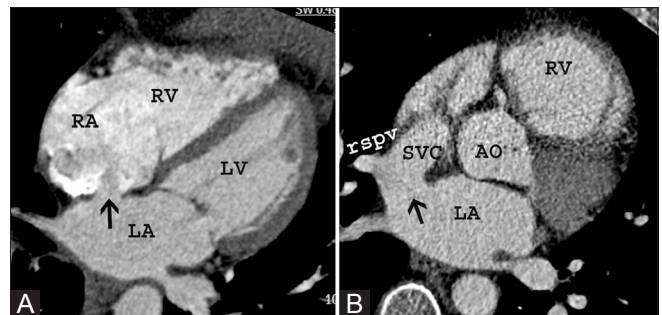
(A, B): Congenital anomalies. Four-chamber CT image (A) shows a defect in the region of the fossa ovalis (arrow), with the contrast jet extending from the left atrium to the right atrium. Axial CT image (B) shows a sinus venosus atrial septal defect (arrow) between the superior vena cava (SVC) and the left atrium (LA). An anomalous pulmonary vein (RSPV) is also seen draining the right upper lobe into the superior vena cava
